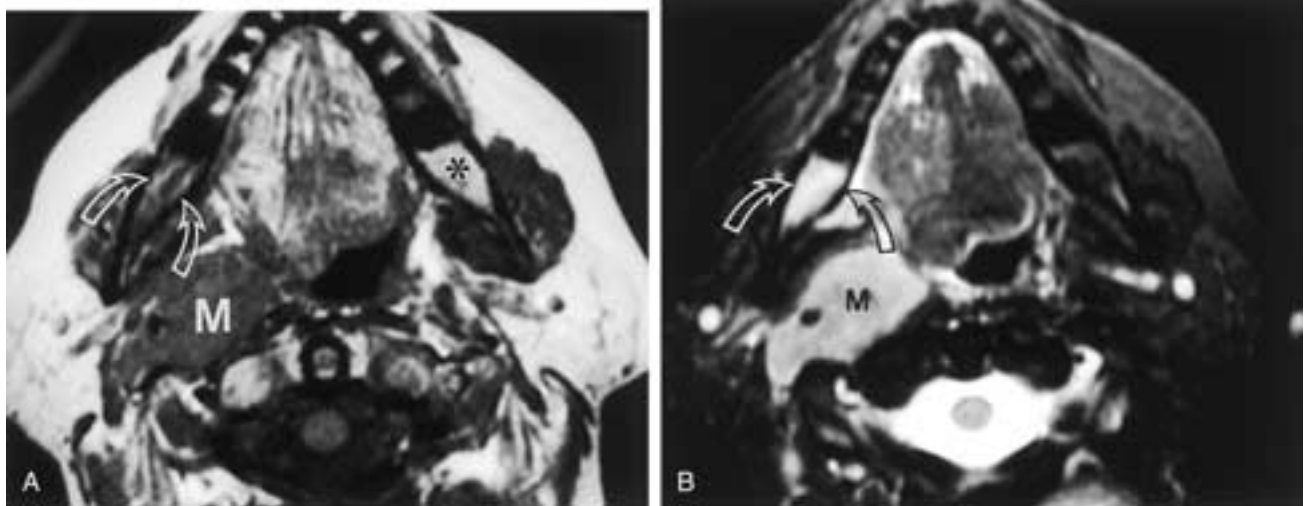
Marrow invasion in the absence of cortical destruction. Axial T1-weighted (A) and T2-weighted (B) MR images demonstrate normal high signal intensity marrow on the T1-weighted image in the left aspect of the mandible (*asterisk*) and lack of normal marrow signal in the right mandible (*arrows* in A). The pathologic marrow demonstrates high signal intensity on the T2-weighted image (*arrows* in B). No evidence of cortical bone erosion is identified. Also note the nearby large myelomatous mass (M), as well as the fatty replacement and prolapse of the right hemitongue from denervation atrophy in this patient with myeloma. (Courtesy of Dr. Thomas Underhill.)
